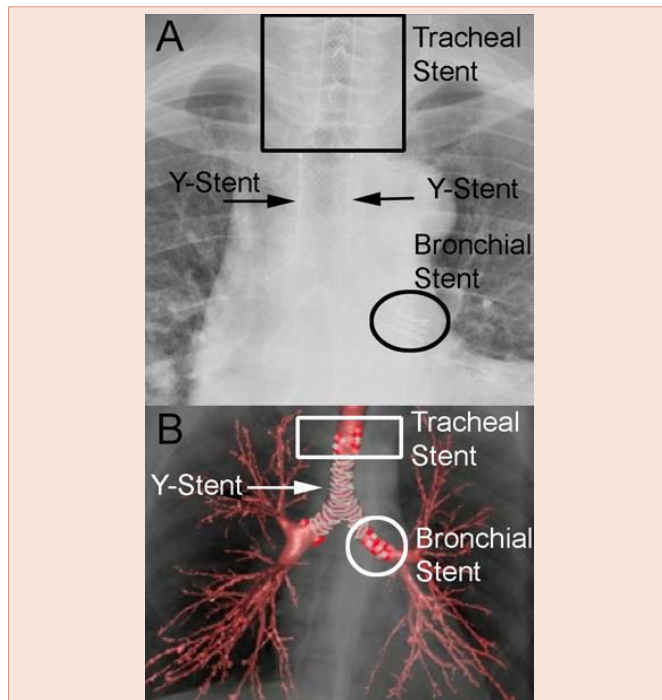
Chest-X-ray (Part A) and Computed tomography scan with 3D reconstruction (Part B) showed the presence of Y-Stent and of the additional two SEMSs within trachea and left main bronchus (Part B). Notably, the complete re-expansion of both lungs without sign of atelectasis.
